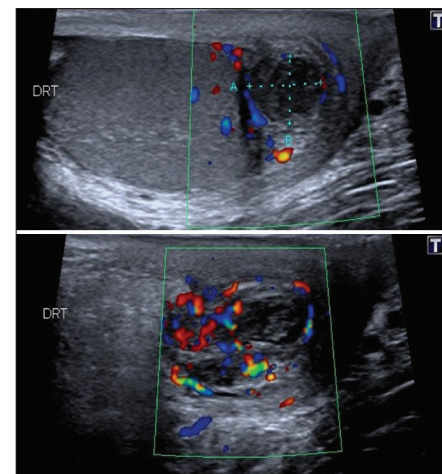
Color Doppler ultrasound in the longitudinal plane of the right epididymal tail
